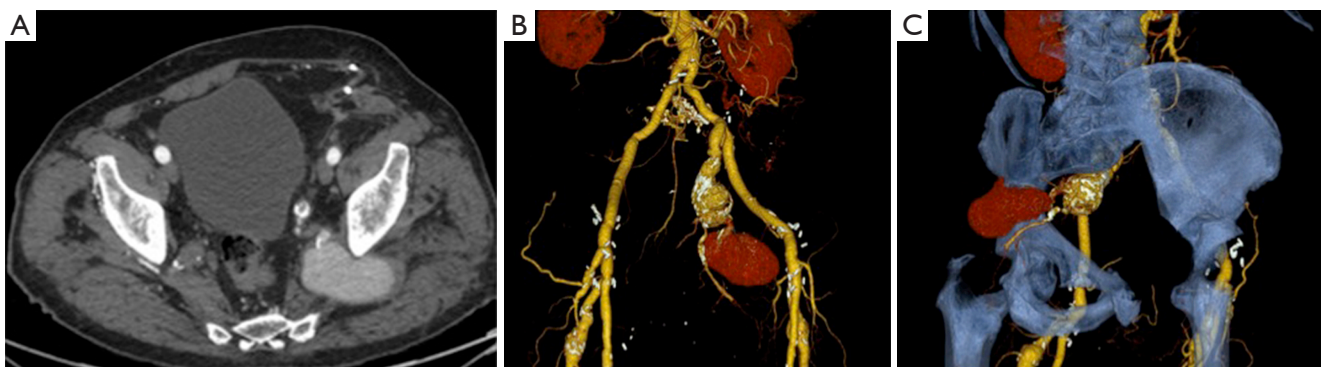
CT images of the pelvis. (A) Axial contrast-enhanced CT of the pelvis showing a giant aneurysm of the left Superior gluteal artery with a large extrapelvic and a small intrapelvic components; (B,C) volume rendering technique reconstructions showing aneurysm extension through the greater sciatic notch and its origin from the superior gluteal artery. CT, computed tomography.
